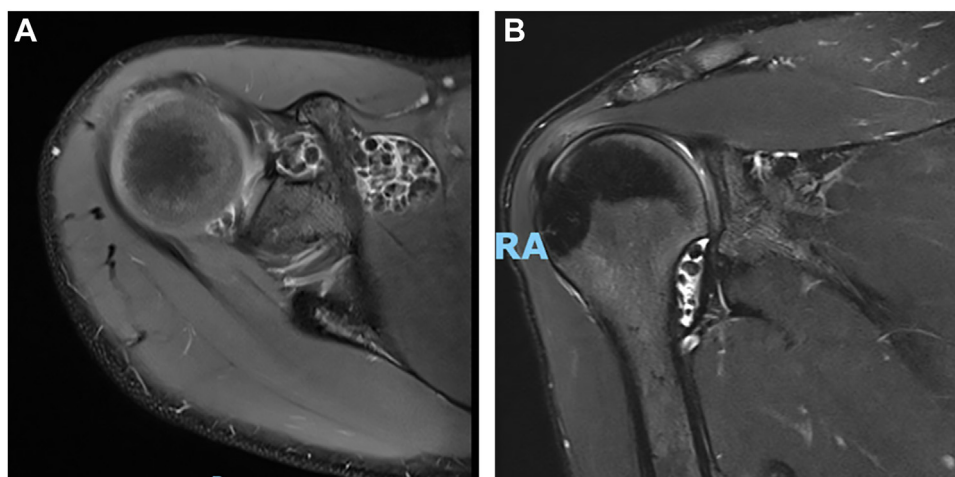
(A) Axial MRI of the right shoulder demonstrating loose bodies medial and lateral to the coracoid. (B) Coronal MRI of the right shoulder demonstrating loose bodies in the axillary recess. MRI, magnetic resonance imaging; RA, right arm.
